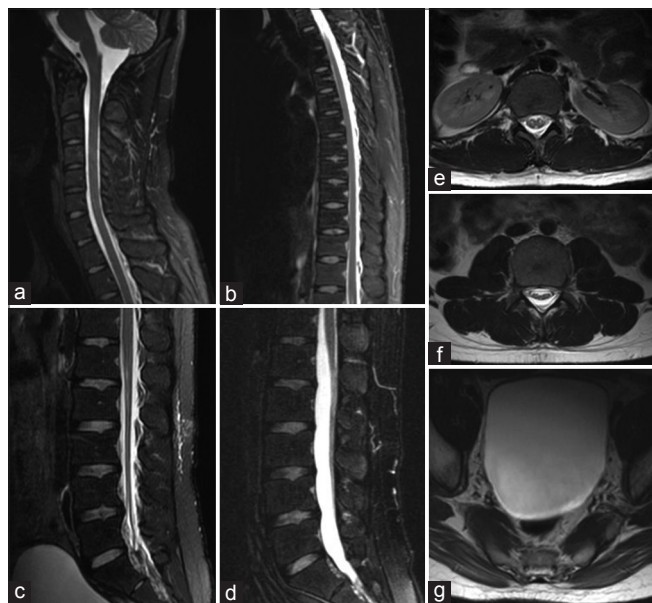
MRI visualization of epidural CSF collection extending from lumbar spine to C7-T1 in an adult patient following LP. (a) Sagittal T2 fast relaxation fast spin echo (FRFSE) MRI image of the cervical and upper thoracic spine C7-T1. (b) Sagittal T2 FRFSE image of the entire thoracic spine. (c) Sagittal T2 FRFSE image of the lumbar spine. (d) Sagittal T2 FRFSE image of the lumbar spine at 6-week follow-up. (e and f) Axial T2 FRFSE image at the levels of L1 and L3, respectively. (g) Axial T2 FRFSE image visualizing the bladder, showing considerable urinary retention
